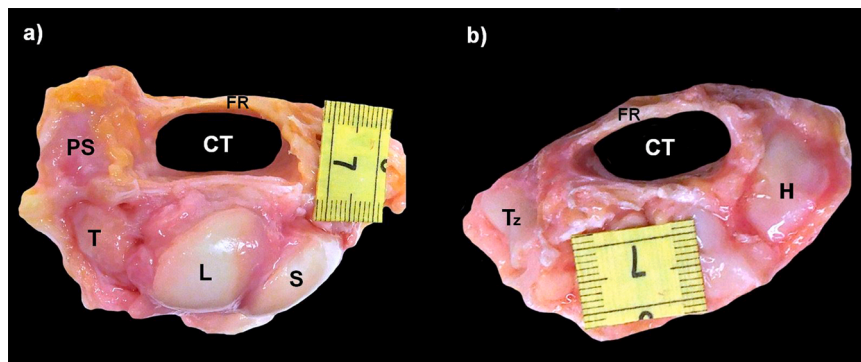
Proximal (a) and distal (b) view of the carpal tunnel. FR=Flexor retinaculum, CT=Carpal tunnel, PS=Pisiform, T=Triquetrum, L=Lunate, S=Scaphoid, Tz=Trapezium, H=Hamate.
